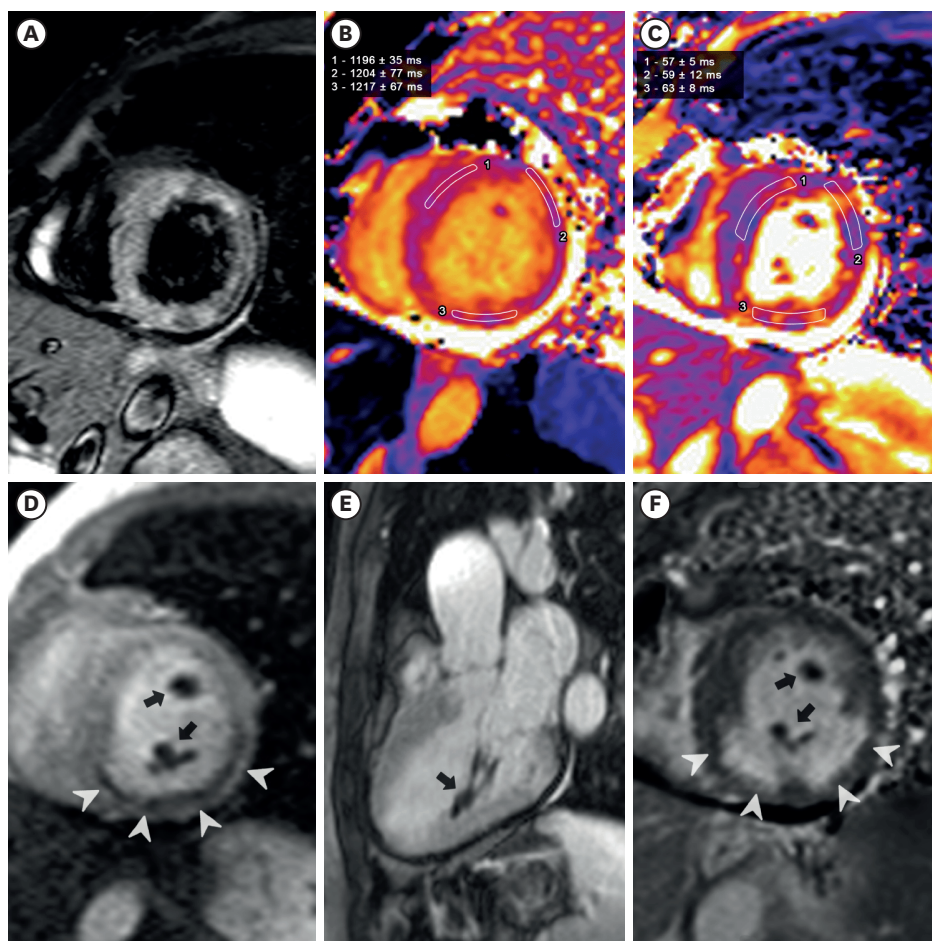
Short-tau inversion recovery sequence (A) showing diffuse hyperintensity in the myocardium. Native T1 and T2 times are also diffusely increased (B, C), supporting a diffuse ischemic insult. The inferoseptal, inferior and inferolateral walls show a fixed perfusion defect in magnetic resonance imaging perfusion imaging and LGE (D, F, arrowheads), suggesting a localized myocardial infarction. The perfusion imaging, early and LGE show hypoenhancement of the papillary muscles (D-F, arrows), a finding compatible with microvascular obstruction of this region. LGE: late gadolinium enhancement.
